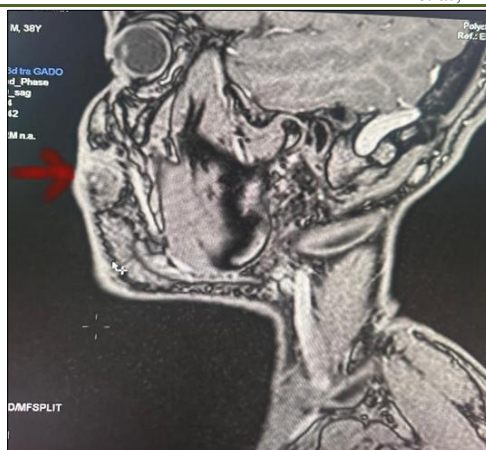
Axial MRI in T1 sequence with gadolinium injection, showing a heterogeneous tissue mass in the right cheek infiltrating the surrounding soft tissues and fat
